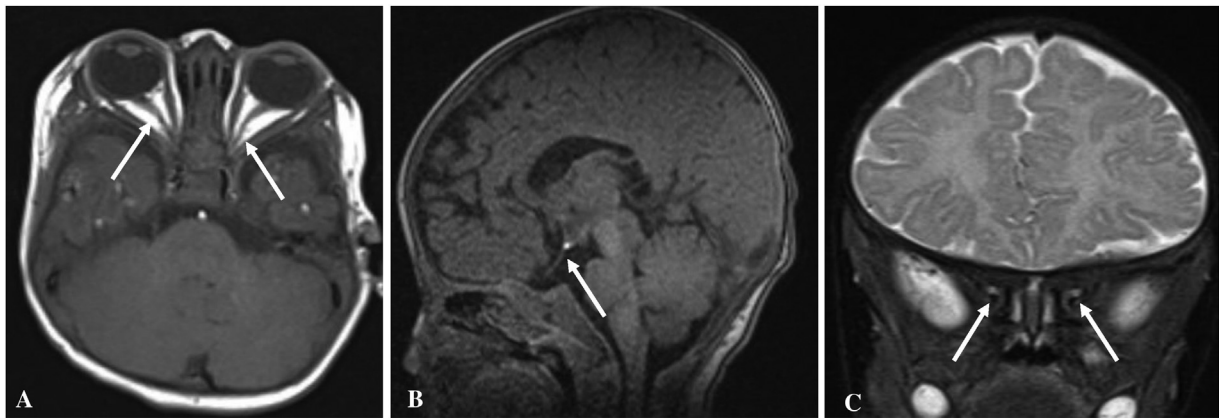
A 10 months old male infant patient presented with reversal of milestones. On ophthalmoscopy, bilateral small optic discs were seen. Axial, sagittal T1-weighted (T1W), and coronal T2W magnetic resonance imaging (MRI) images demonstrating ectopic T1W bright spot, located at the median eminence with isolated bilateral hypoplastic optic nerves.
